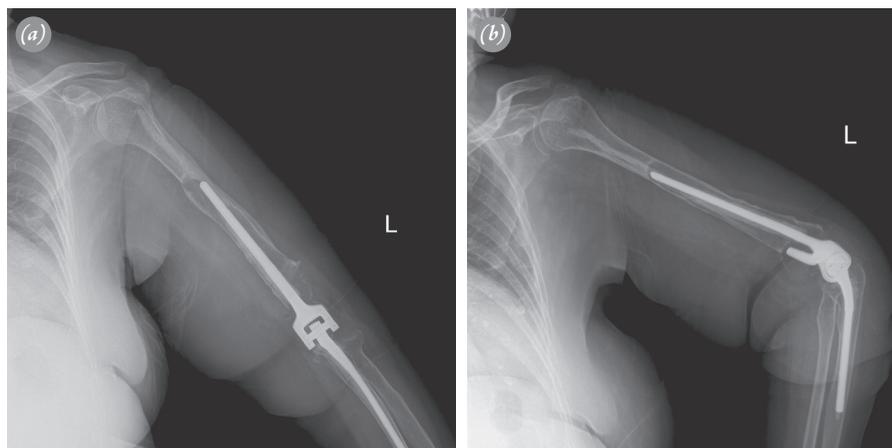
(a, b) Radiographs of Type 4 humeral loosening (Case 5).
